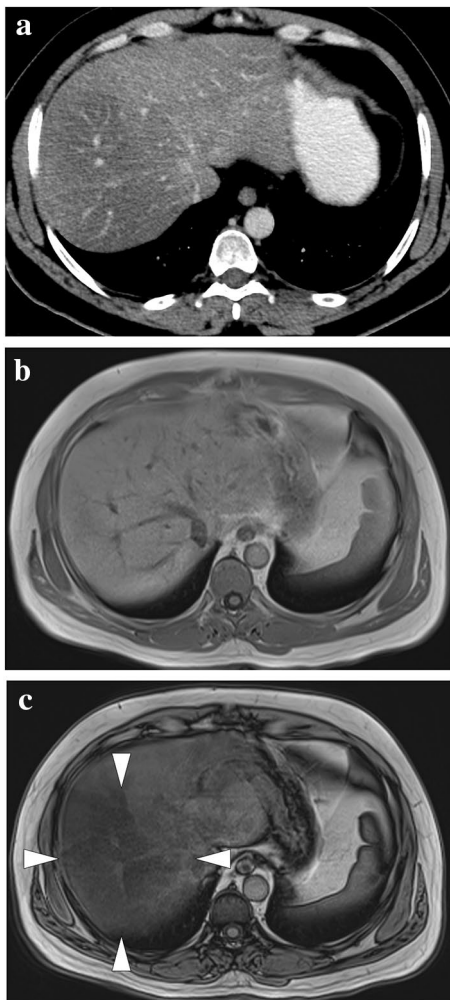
A 44-year-old male patient with known squamous cell carcinoma of the tongue. a Axial plane postcontrast abdominal CT showed a large hypodense area within the right liver lobe with a relatively sharp demarcation line from the remaining parenchyma (arrowheads). b and c In (b) and out (c) of phase MR images confirmed the presence of focal hepatic steatosis (arrowheads)
